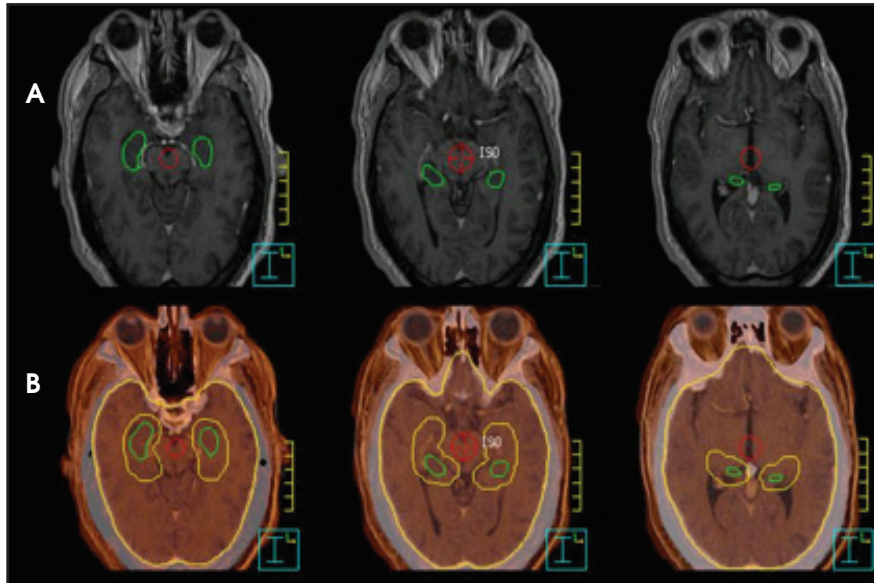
(A) The contours of the hippocampus are shown in T1-weighted contrast-enhanced MP-RAGE MR images (grayscale); (B) the contours of PTV (the outer yellow line), hippocampus avoidance (inner yellow line), and hippocampus (green line) are shown in the fused MR (thermal)/CT images for a selected patient.
